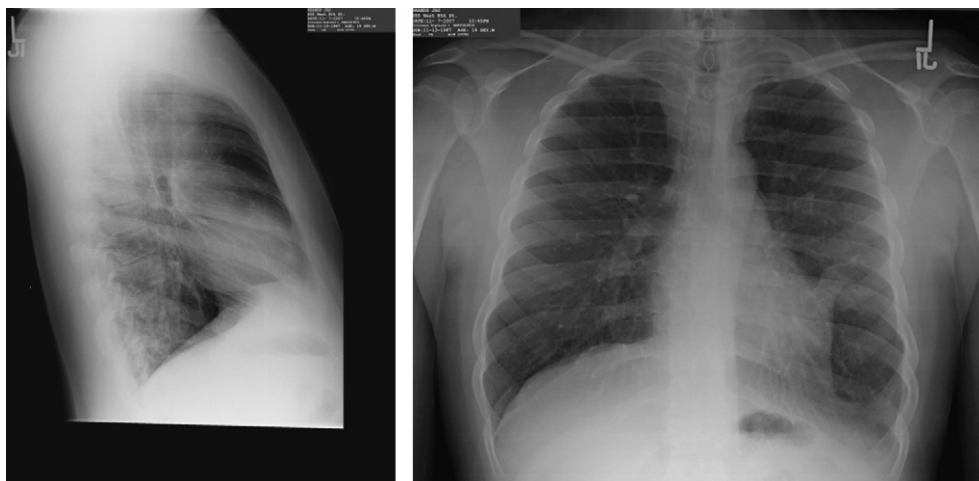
Postero-anterior and lateral chest radiograph showing scarring in left lung at the site of surgical lung biopsy.
